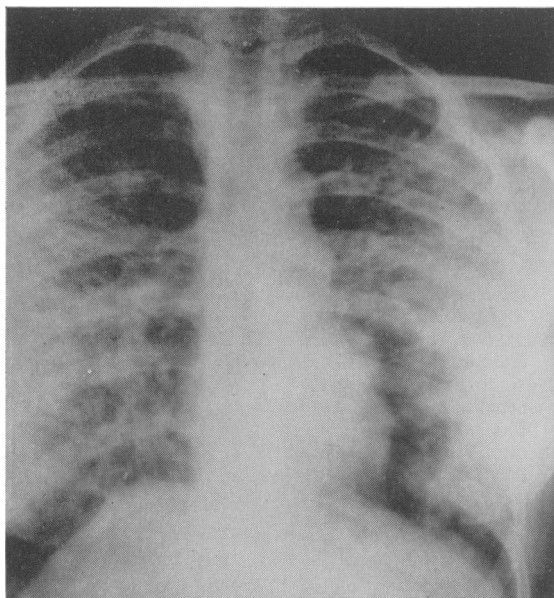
Radiograph of chest, 1933, showing widespread linear and coarsely mottled opacities, densest in the middle zones of the lungs.
